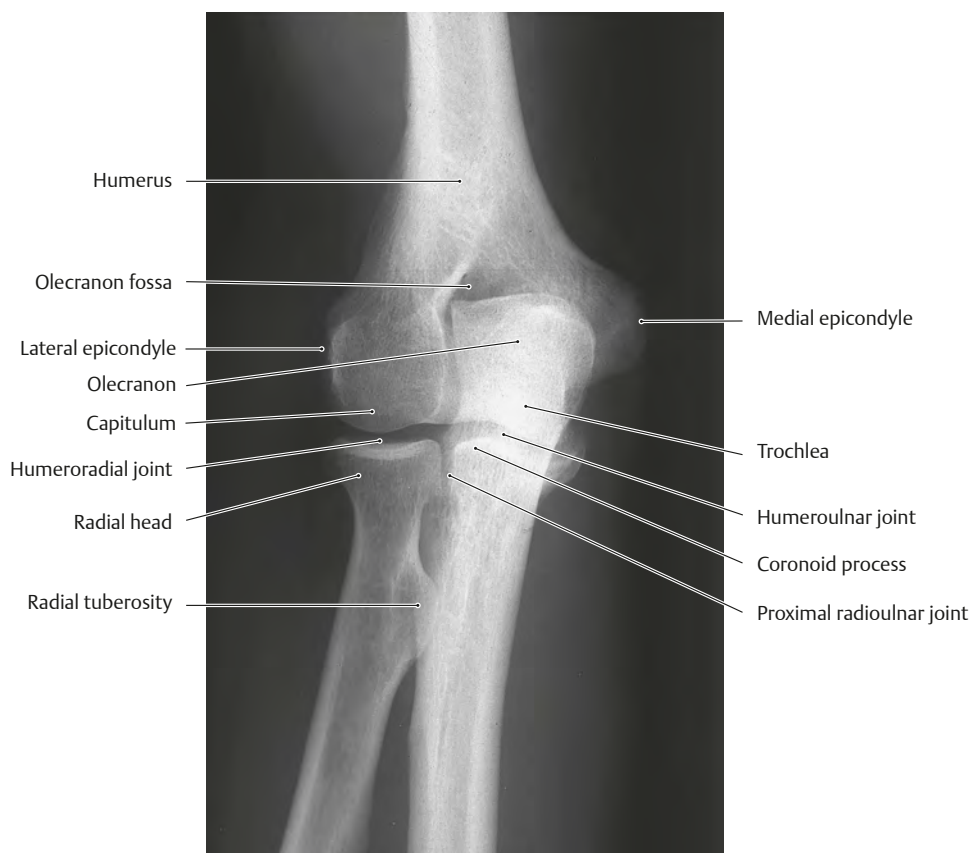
Radiograph of the elbow
